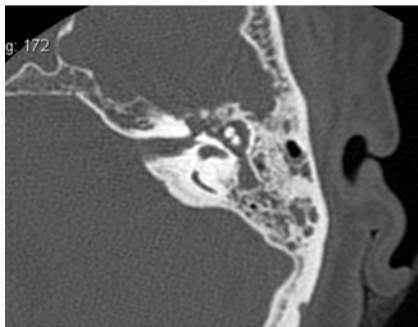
HRCT temporal bone, axial cut showing defect in the tegmen tympani in the region of attic with opacification of antrum and middle ear.
